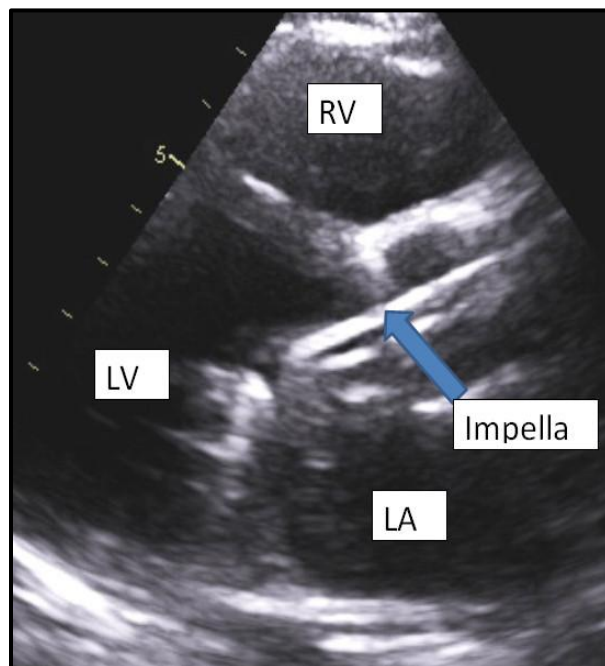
Echocardiogram showing right ventricle (RV), left ventricle (LV), left atrium (LA) and Impella device. LVEF= 15%.
